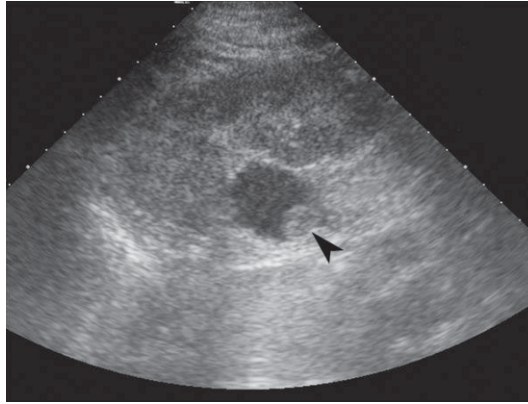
Ultrasonography. Transitional cell carcinoma. Solid lesion in the right renal pelvis (*arrowhead*)
